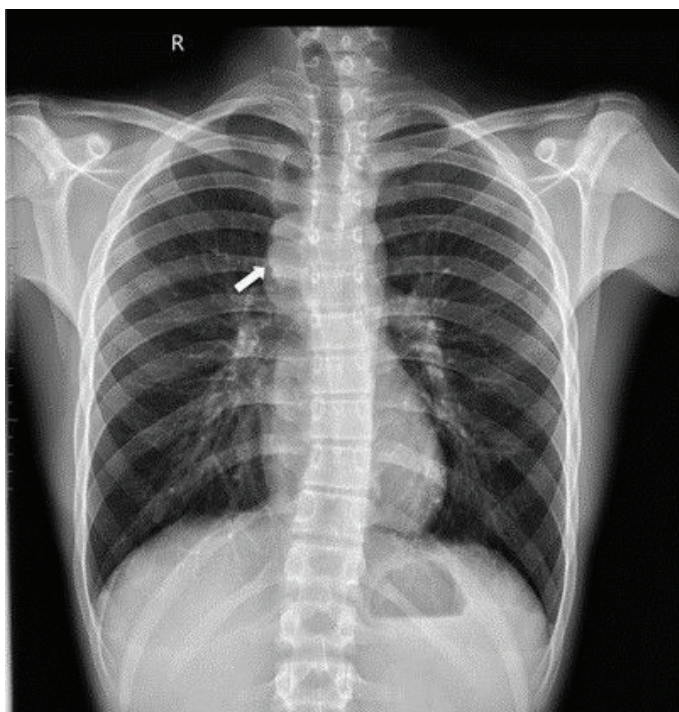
Posteroanterior chest radiograph shows a nodular opacity with smooth contour in the right paratracheal area (white arrow).
